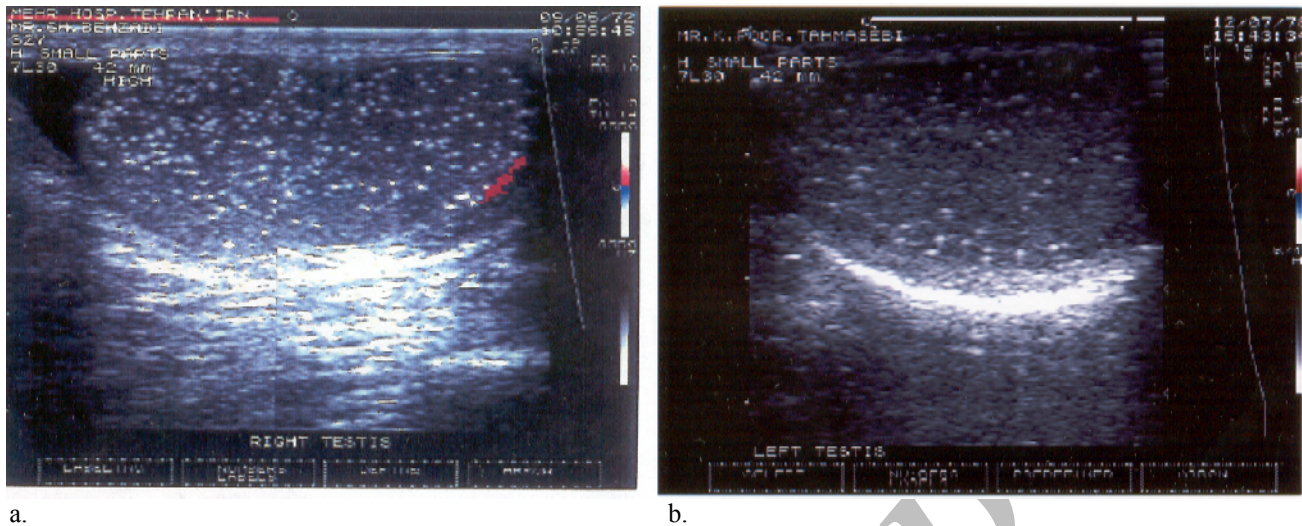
Typical sonographic appearance of testicular microlithiasis in different patients. Note more profuse microliths in figure 'a' in a patient with azoospermia
